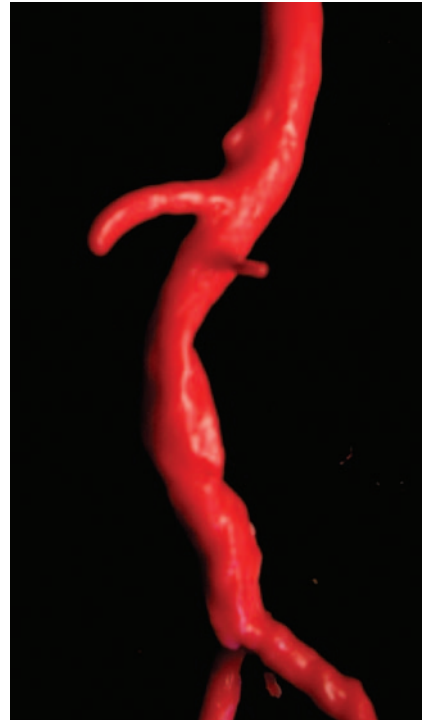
Molded wax replica created from his CT angiographic data.
